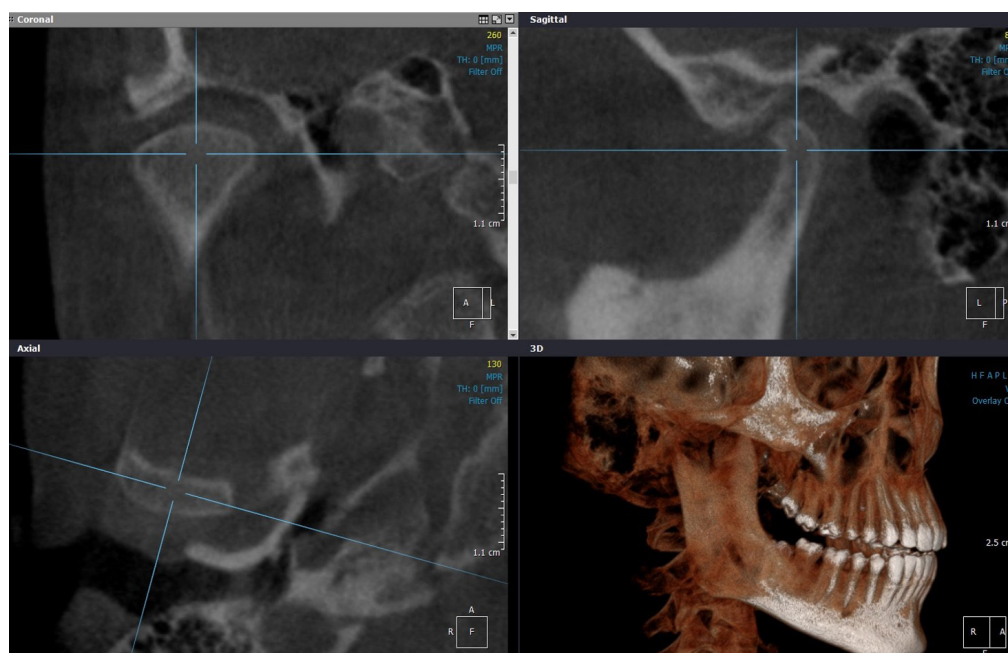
CBCT Corrected Sagittal view of the right TMJ shows the osteophyte formation in the superior anterior aspect.
